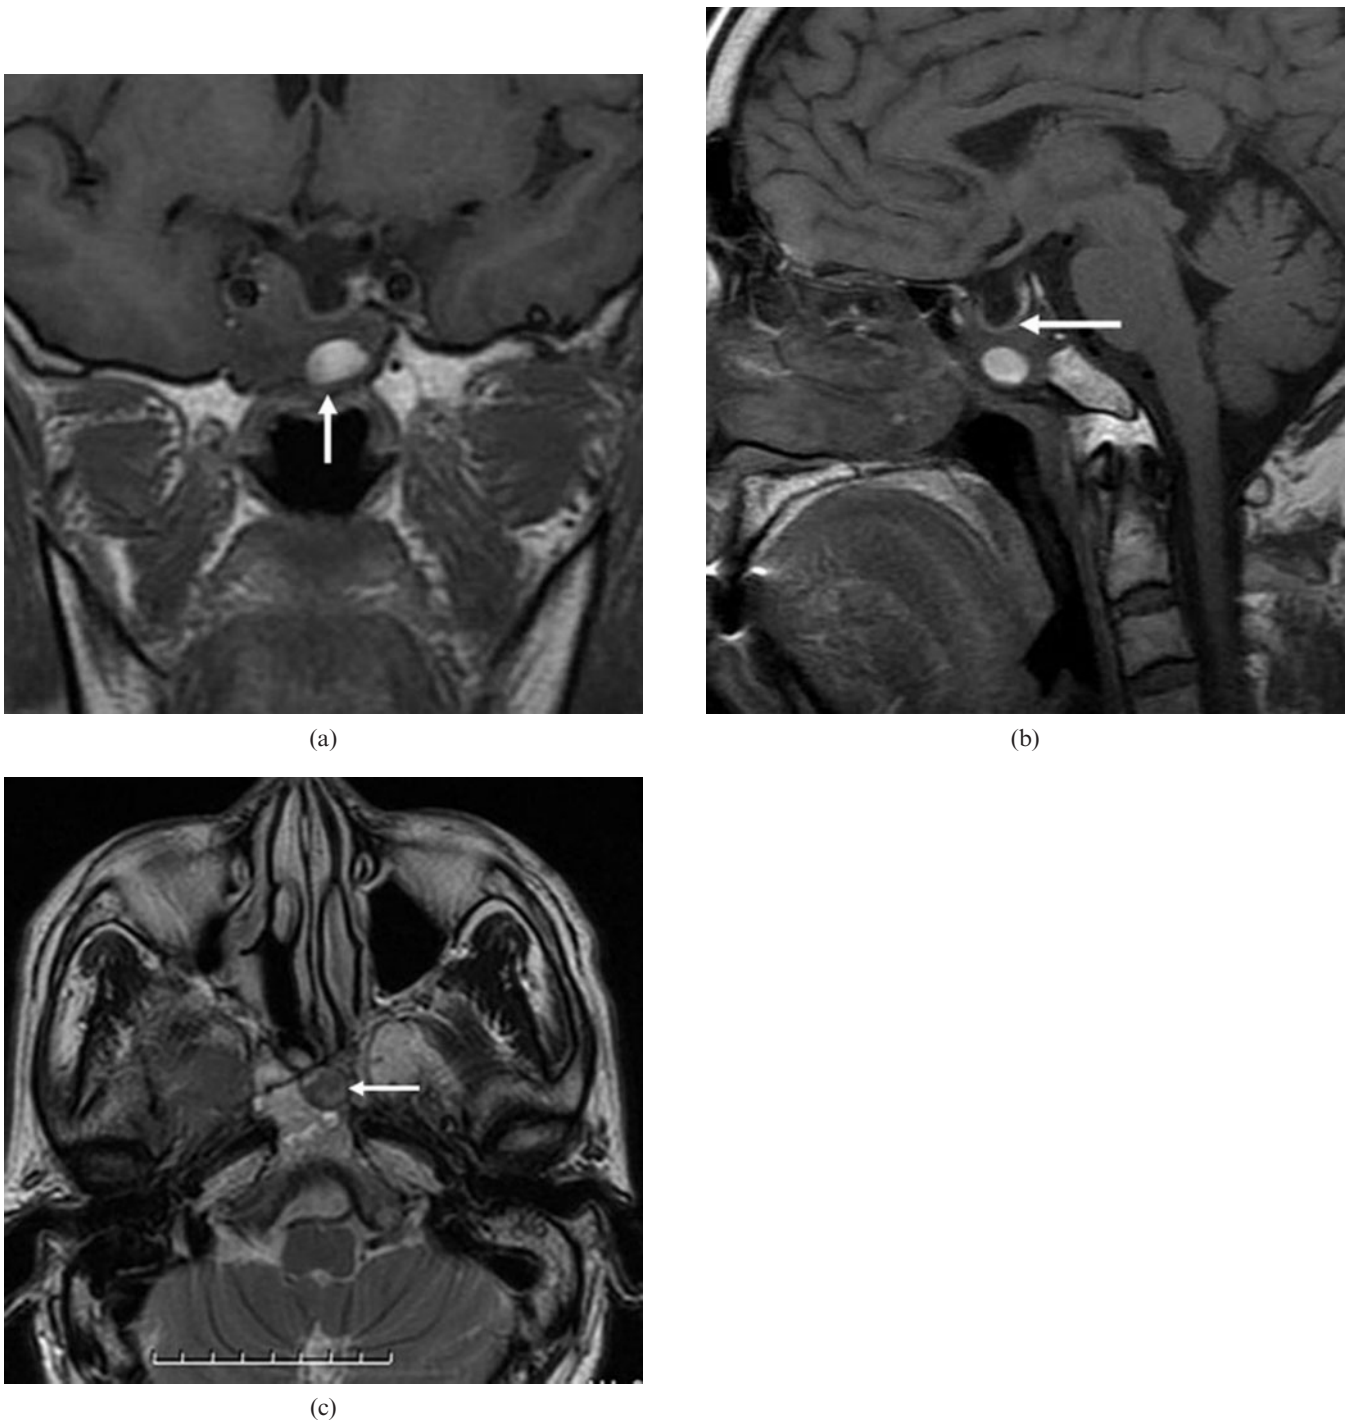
(above) Patient 5 (had right nasal cavity endoscopic sinus surgery owing to a papilloma 10 years ago). (a) Coronal T_1 weighted MR image shows heterogeneous sphenoid sinus ectopic pituitary adenoma with an area of high signal intensity (arrow), suggesting proteinaceous secretions. Note the presence of an empty sella and encasement of the right internal carotid artery. (b) Sagittal T_1 weighted MR image shows an empty sella and intact sellar floor (arrow). Note the erosion of the adjacent clivus. (c) Axial T_2 weighted MR image shows a sphenoid sinus mass of slightly high signal intensity with area of low signal intensity (arrow). Note the erosion of the adjacent clivus.
